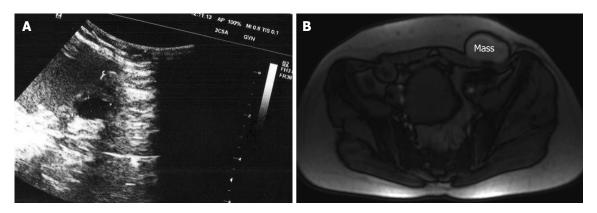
Ultrasonographic view (A) and magnetic resonance imaging (B) of scar endometrioma.
